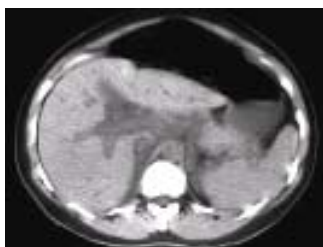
Unenhanced CT image of the Liver Demonstrates Periportal Edema (arrow) and Fluid in Morison's Pouch
